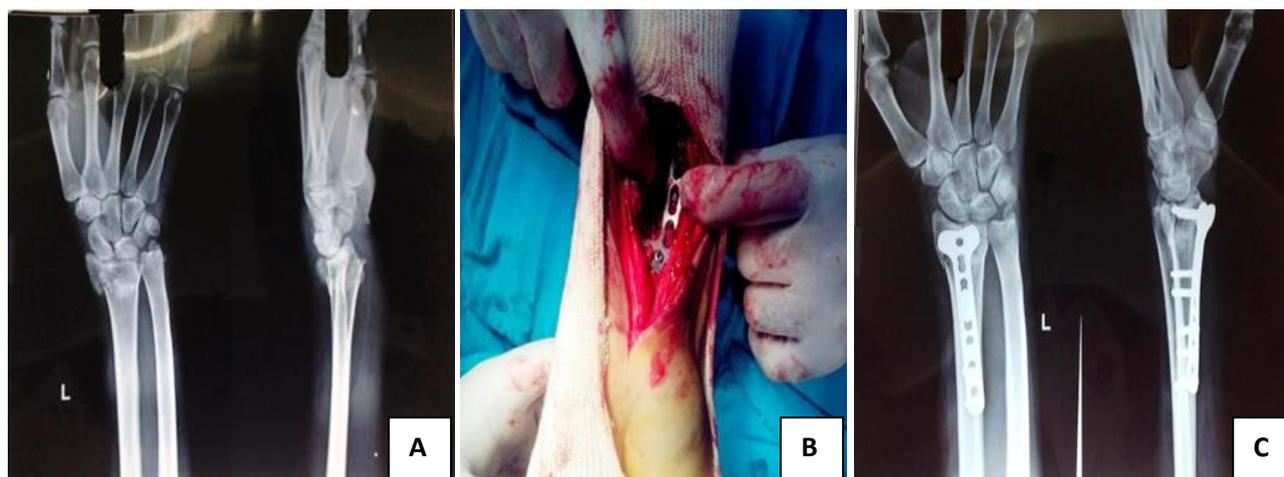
A,B,C: Pre-operative x-rays, Intra-operative & Post-operative
